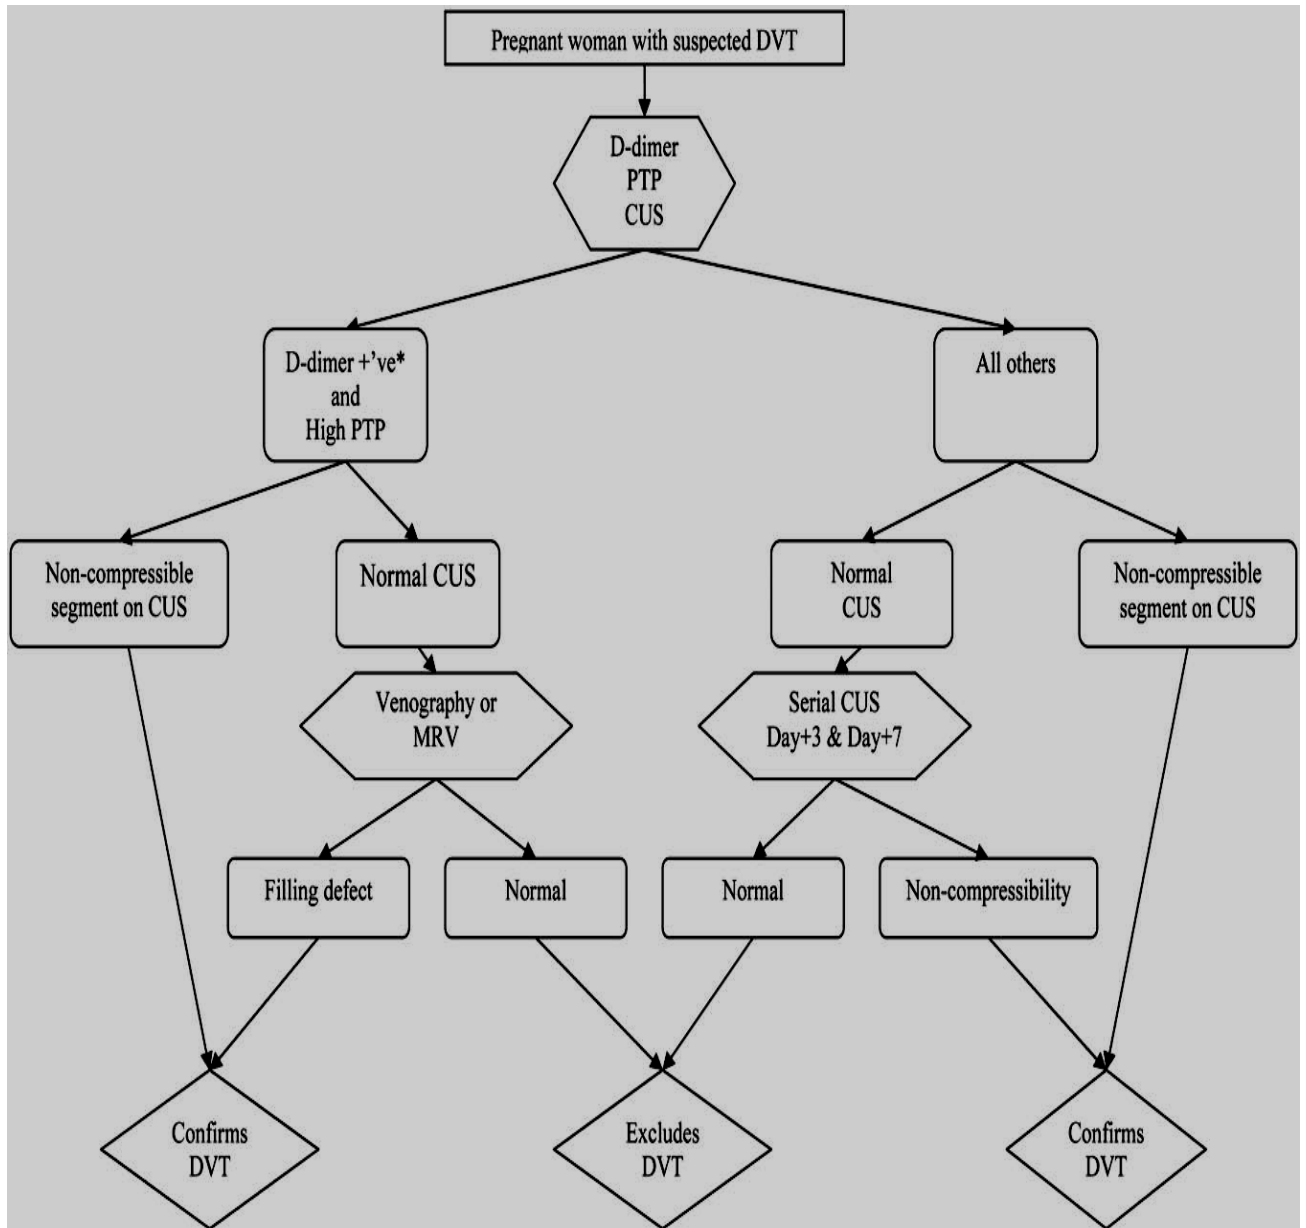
Algorithm for suspected DVT in pregnant women. *Using nonpregnant D-dimer cutoff (i.e., usual D-dimer cutoff in local practice). CUS=venous compression ultrasound imaging; PTP= pretest probability, MRV= Magnetic Resonance Venography ²⁹.
